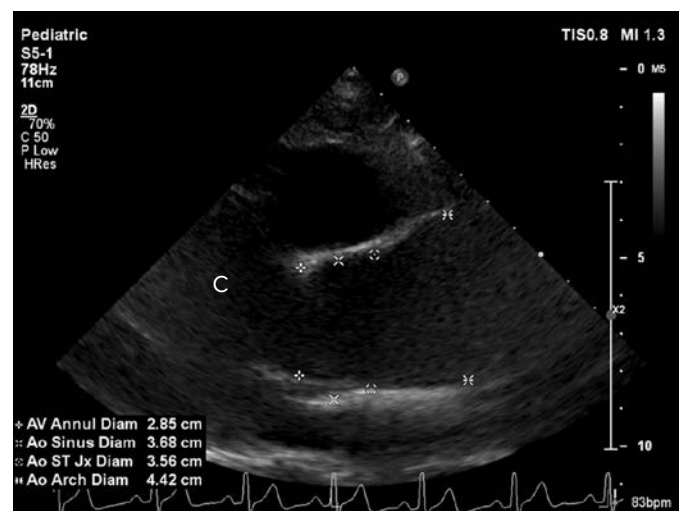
Aortic measurement, transthoracic echocardiogram parasternal long axis view. Ao Arch Diam, aortic arch diameter; Ao Sinus Diam, aortic sinuses diameter; Ao ST Jx Diam, aortic sinotubular junction diameter; AV Annul Diam, aortic valve annular diameter.
